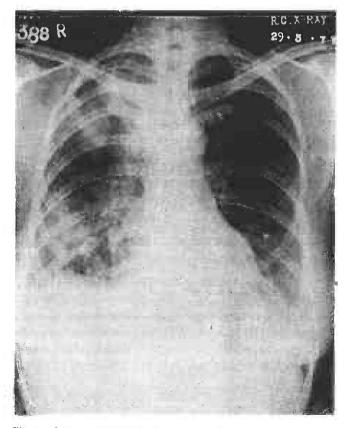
Chest radiograph showing opacities in the right lung and left lower lobe.
